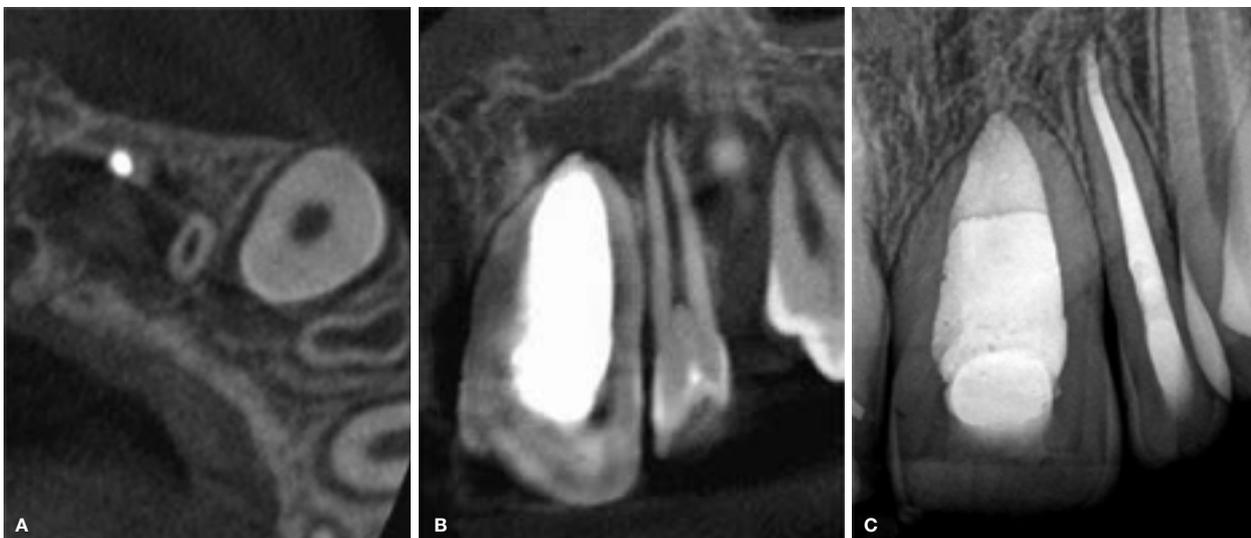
Limited field-of-view CBCT showing: (A) the axial view at the level of the root apex of the left maxillary lateral incisor. Note the large periapical lesion extending mesially to the obturated central incisor; (B) the coronal view confirming the large periapical lesion. (C) Postoperative 2-year follow-up radiograph confirming good healing of the periapical pathology after treatment of both teeth.
